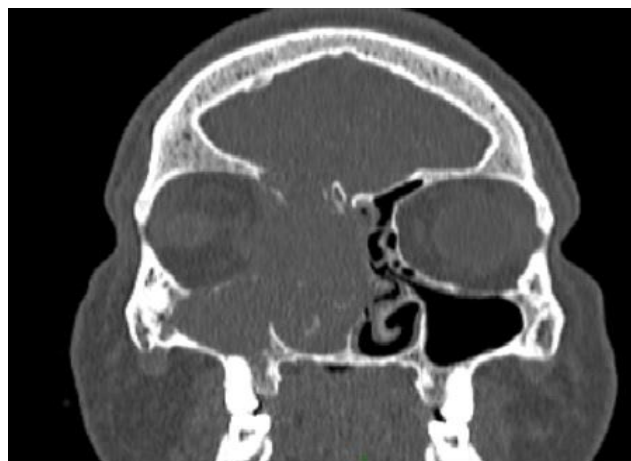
CT PNS (coronal view) showing right nasal mass causing erosion of adjacent bone and extension into right extraconal compartment.
